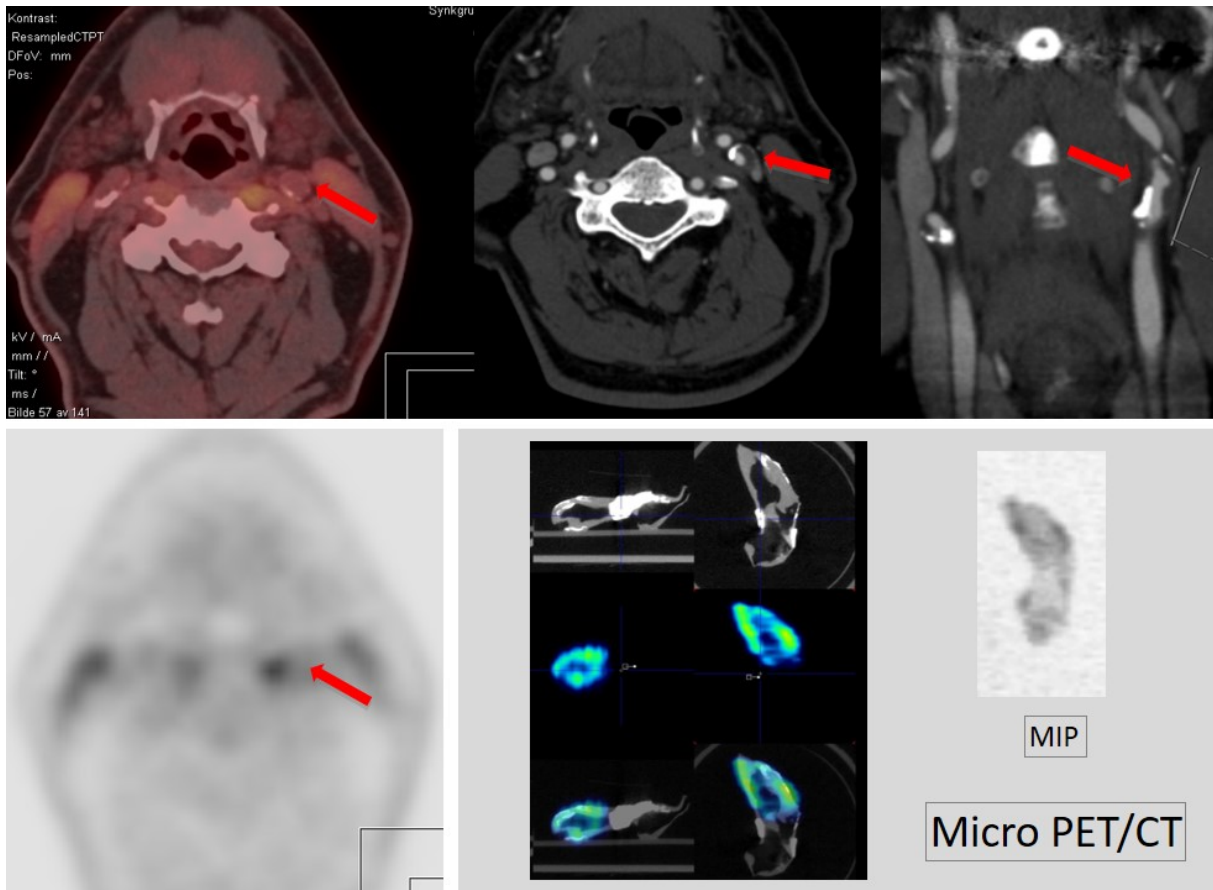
Patient with low/medium uptake on human PET (lower panel left) (max SUV_{max} 1.82, mean SUV_{max} 1.51) and with microPET max SUV_{max} 11.7. The CTA shows a mixed plaque containing calcifications and low-attenuating areas stretching 2.5 cm cranially with severe stenosis (upper panel middle and right). The patient had experienced symptoms nine months earlier and the plaque was echolucent on ultrasound examination.
